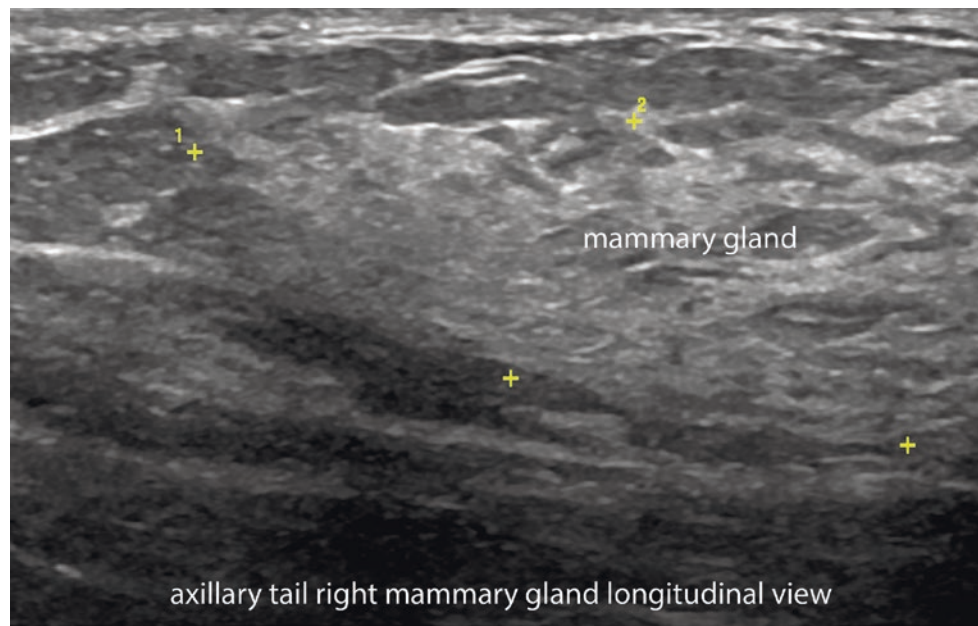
Normal ultrasound morphology of the tail of the mammary gland at the base of the axillary region (between markers; longitudinal view).
